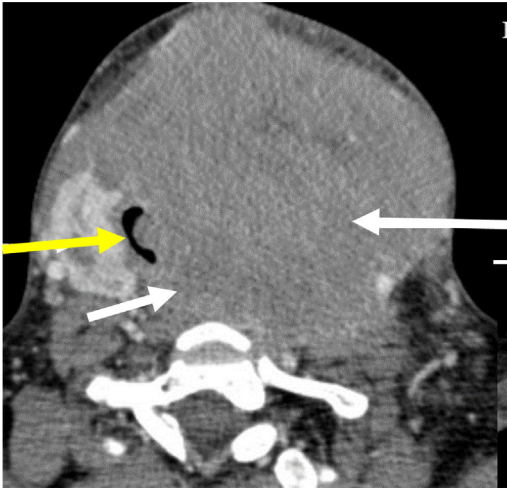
Esophageal and tracheal invasion. Axial contrast-enhanced CT shows a large mass (*long white arrow*) extending medially to invade the trachea (*yellow arrow*) and extending posteriorly to involve the cervical esophagus (*short white arrow*).
